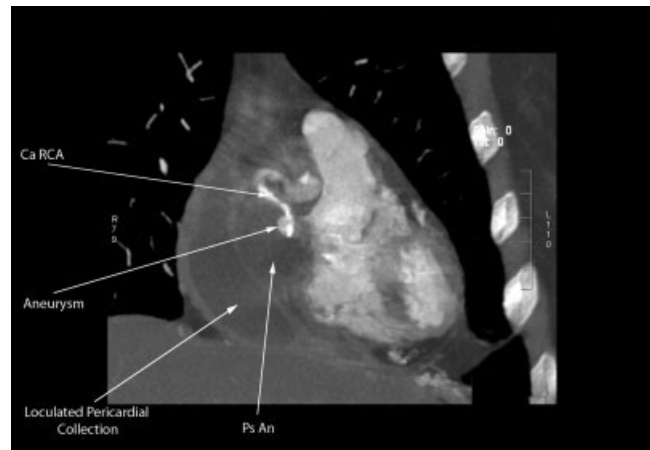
Computed tomography demonstrating a calcified right coronary artery (Ca RCA) associated with a saccular aneurysm surrounded by a large pseudoaneurysm (Ps An) and a loculated pericardial collection.
